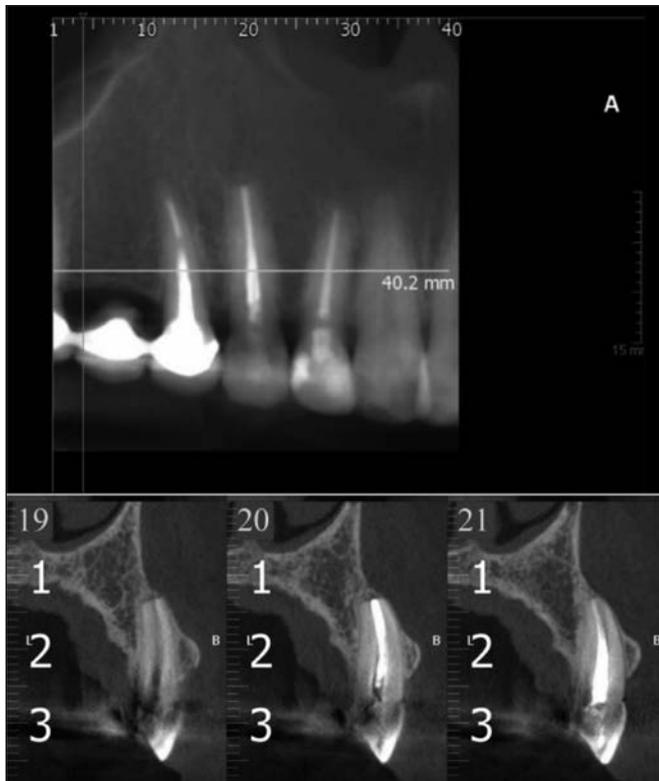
Transaxial sections of volumetric computed tomography of tooth 13
